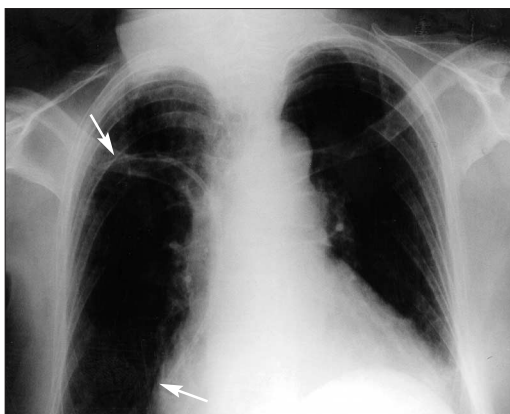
A chest X-ray of a female adult. An oncology senior house officer attempted removal of a Hickman line on a general ward. The catheter was inadvertently cut through and the intravascular segment is seen lying between right subclavian vein and right atrium (arrows). The end of the catheter lying behind the clavicle could not be found outside the vein by a vascular surgeon and was removed via radiological snaring from the groin.
